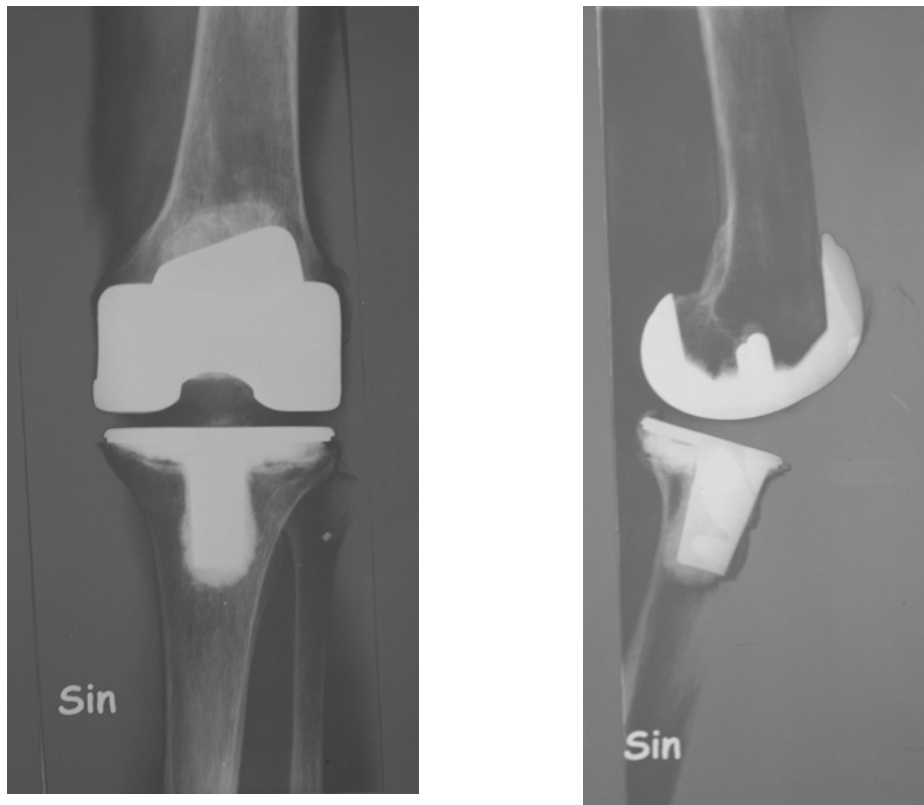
Antero-posterior and lateral radiographs one year postoperatively.
